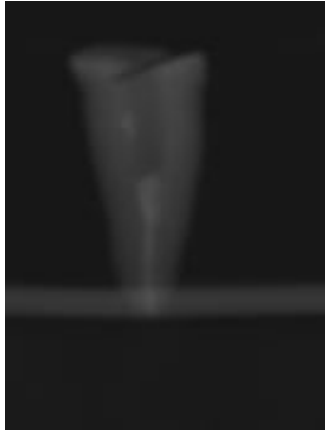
14 Evulion of amount of space by CBCT Fig:15 Sectional evulion of amount of space by cbct
